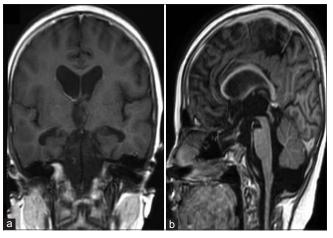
Postoperative magnetic resonance images obtained 2 years after surgery. T1-weighted coronal (a) and sagittal (b) images obtained after gadolinium enhancement show that there is no further pathological enhancement
